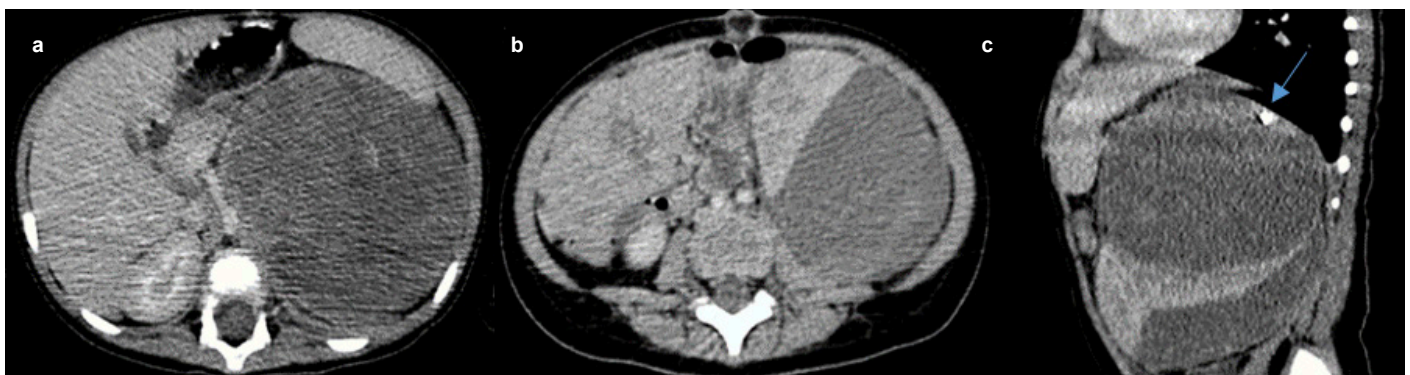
(a-c). Preoperative CT images of the patient. The mass crossed the midline (a). There is a large heterogeneous mass arising from within the left kidney (b). Intratumoral calcification was seen (blue arrow) (c). The left adrenal gland was not able to be identified. CT: computed tomography.
